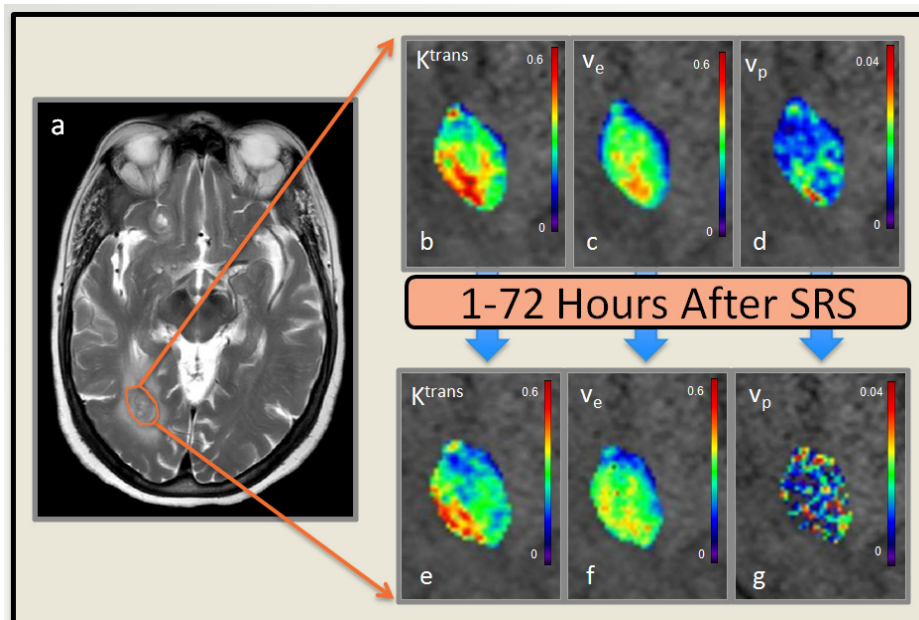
Representative Brain Metastasis patient depicting the early changes in DCE metrics pre- and early post-Tx. a. Brain metastasis contoured on a T1w MRI. b.-e. pre-Tx K^{trans} , v_e , v_p maps. f.-i. Early post-Tx K^{trans} , v_e , v_p maps. All maps overlaid on T1w MRI.
